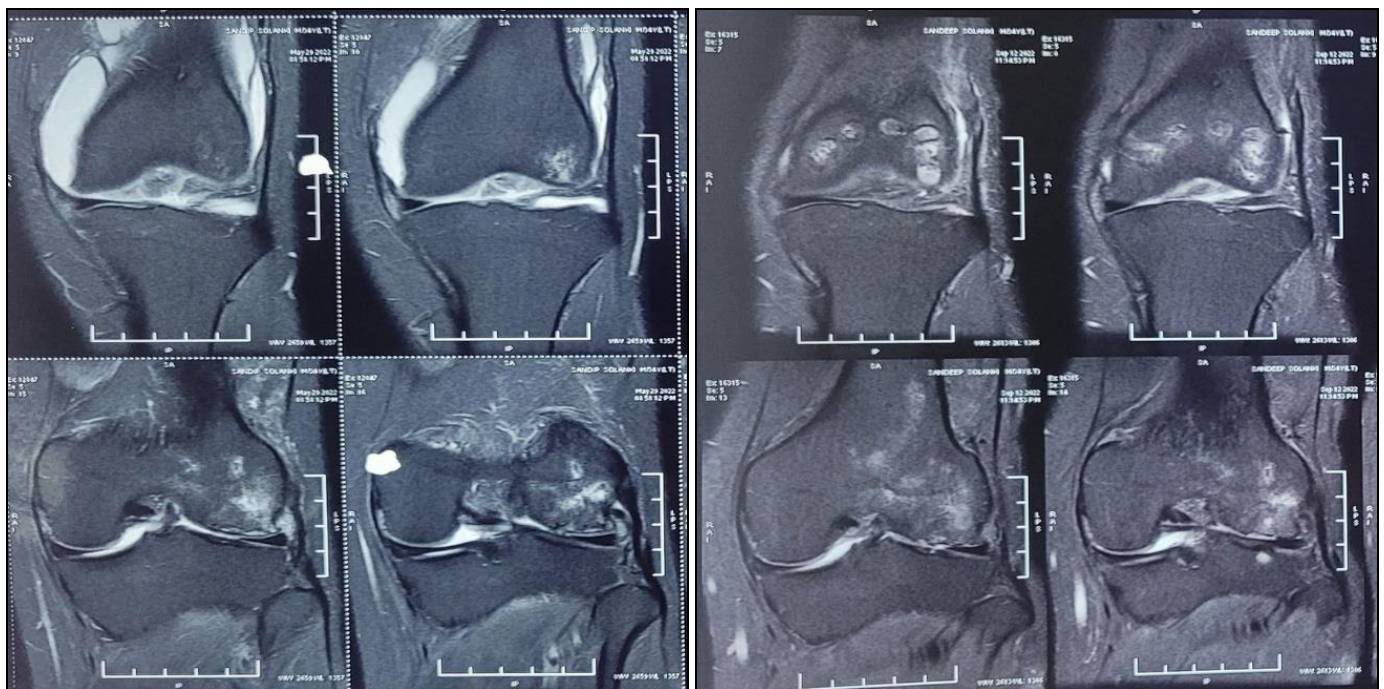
a, b: Image on the left (3a) shows coronal section (preop) T2 weighted MRI with subchondral oedema and necrosis of the lateral femoral condyle. Image on the right (3b) upper side shows postoperative donor area while right lower shows healing in weight bearing recipient area.
